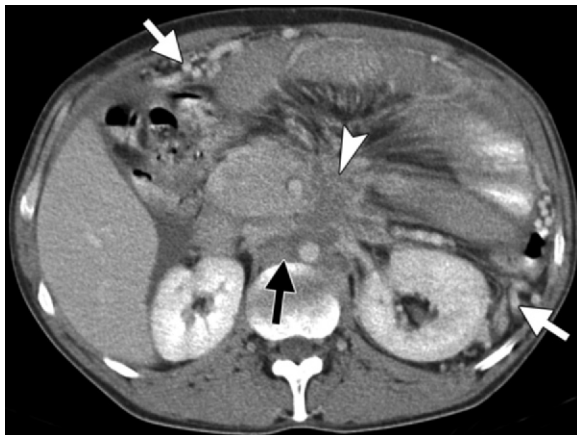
RPF secondary to tuberculosis in a 42-year-old man with human immunodeficiency virus (HIV) infection and a history of tuberculous lymphadenitis who presented with abdominal pain and fever. Axial CT image obtained 60 seconds after contrast material administration shows a markedly hypoattenuating paraaortic mass (black arrow) that infiltrates the pancreatic body (arrowhead) and the superior mesenteric and splenic veins. Note the presence of collateral venous circulation (white arrows) secondary to venous obstruction. A presumptive diagnosis of RPF secondary to tuberculosis was made. Antibiotic treatment was instituted, with improvement in the patient's clinical condition.
